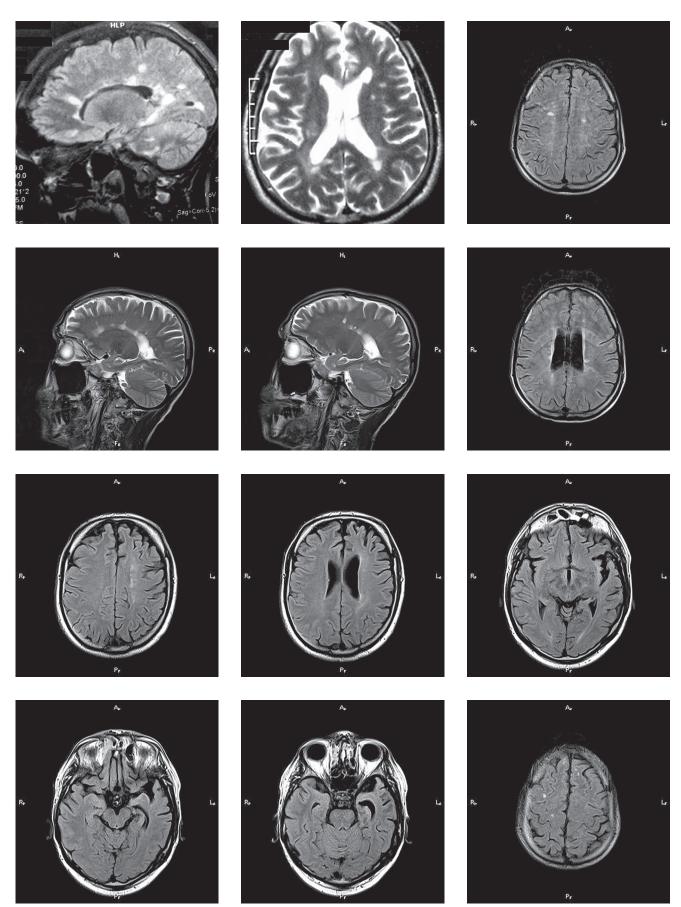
Magnetic resonance images of patients with locally induced epilepsy and multiple sclerosis
